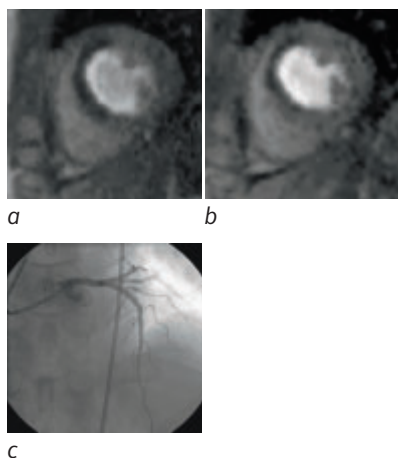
Imaging of a 52 year old male patient following acute myocardial infarct. a) rest perfusion* image, b) stress perfusion image*, and c) X-ray angiogram.
